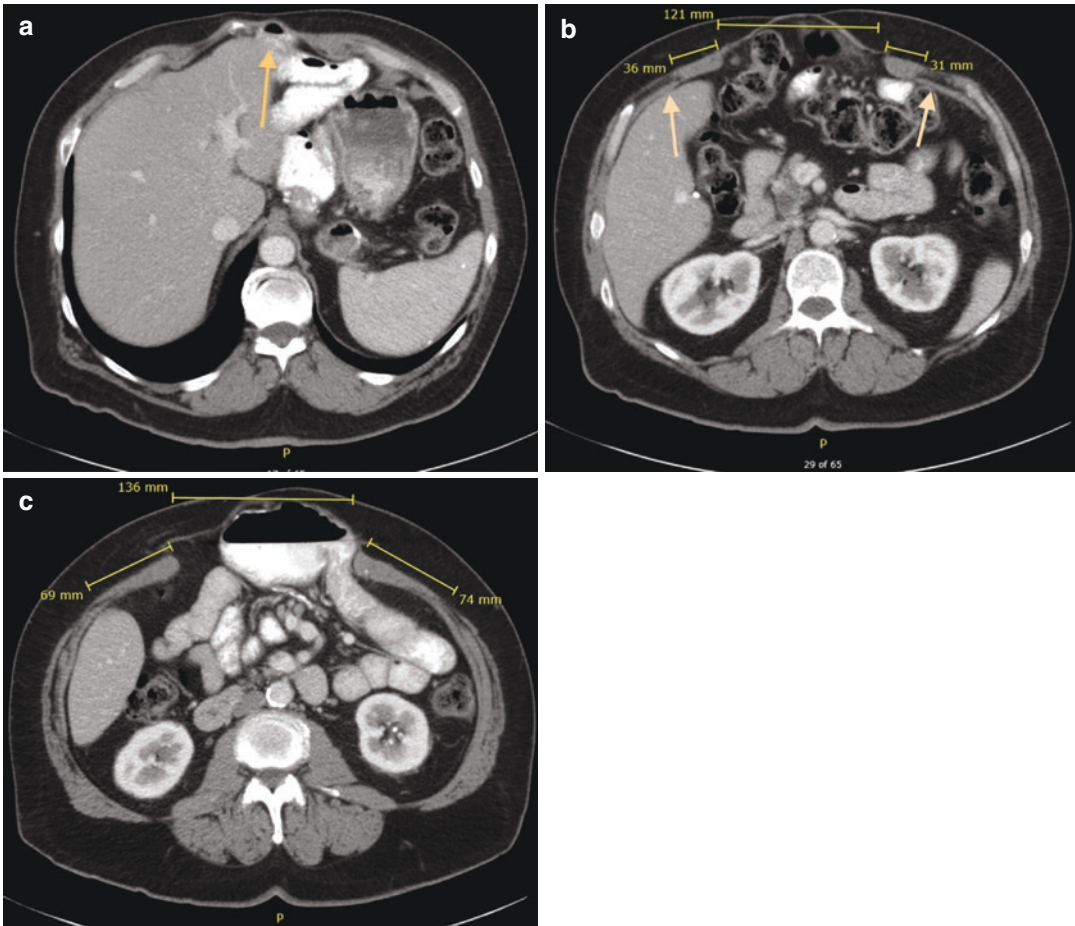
(a) CT showing the hernia defect extending cephalad and to the left of the xiphoid process as a result of the previous laparotomy. (b) Retracted rectus muscles 3.6 and 3.1 cm respectively with a 12.6 cm defect. Arrows identify the transversus abdominis muscle originating on
